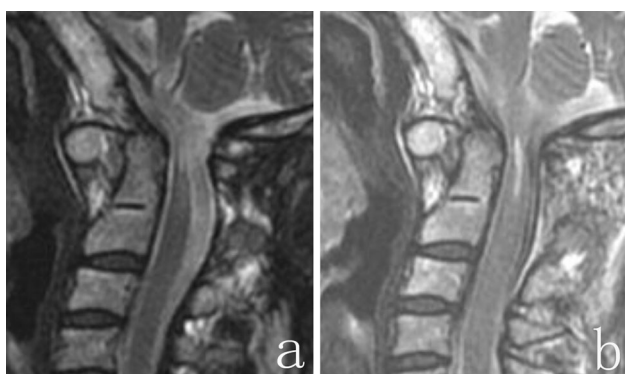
MRI showed a restoration of the damaged spinal cord 1 year after operation (a) compared to 1 week after operation (b)
